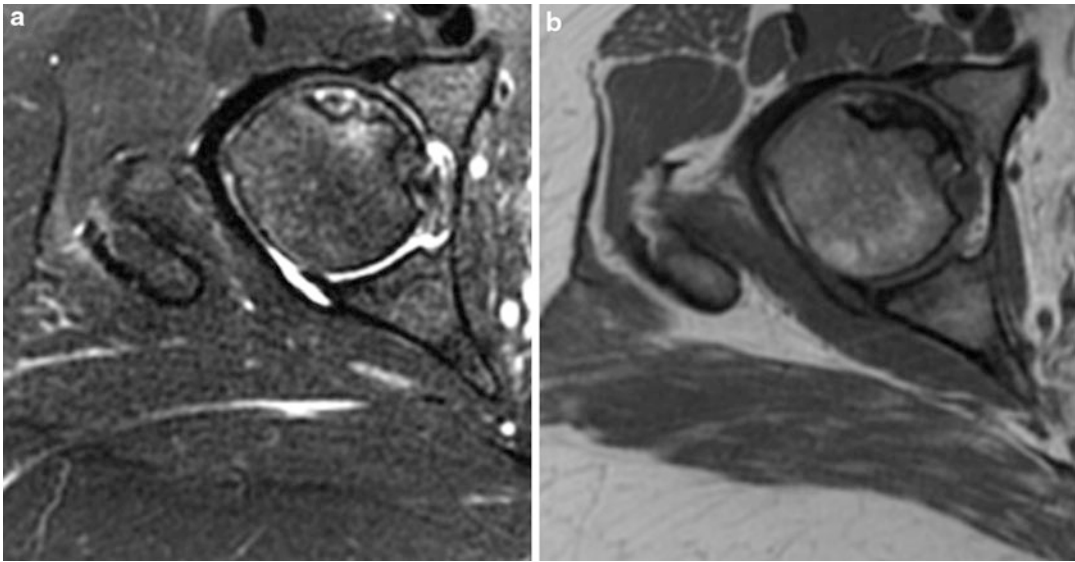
Axial cuts from MRI demonstrating osteonecrosis (ON) of the right anterior superior femoral head (a: T2-weighted image, b: T1-weighted image)
